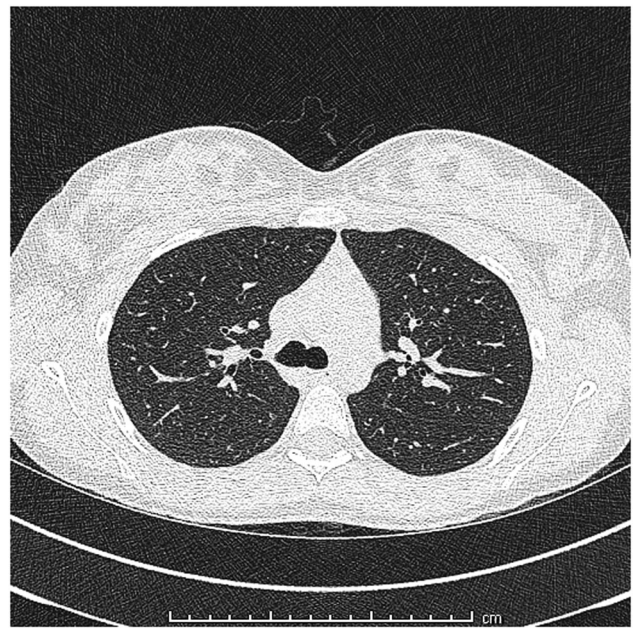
Case 10, chest CT: normal chest CT. CT, computed tomography
